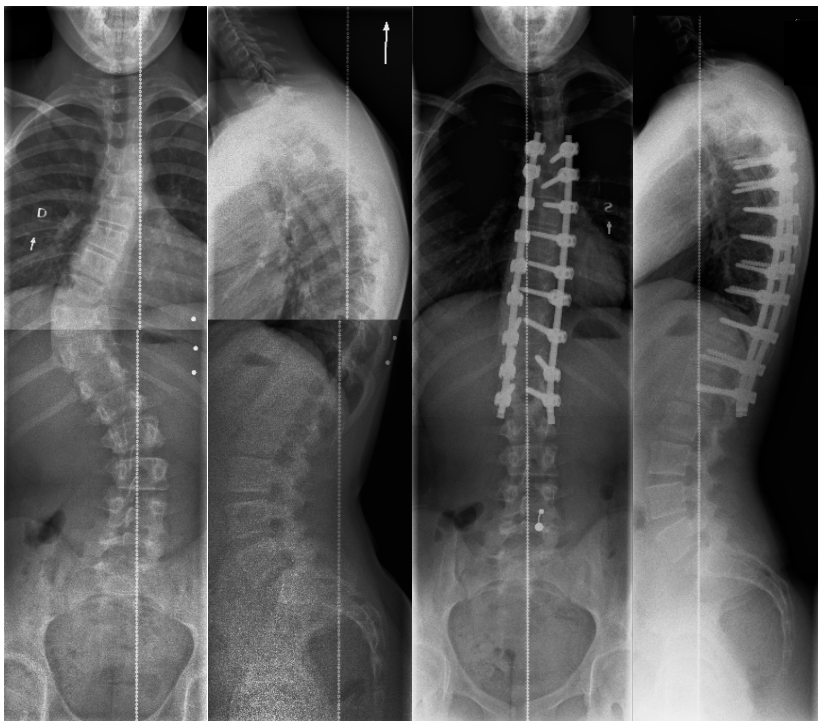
JIS: Figs. 2-A to 2-C. 11-year-old girl with juvenile idiopathic scoliosis (Risser 0). Preoperative standing radiographs (A, B) demonstrate 60-degree thoracic scoliosis. Standing radiographs (C, D) at two-year FU demonstrate fusion after PSI with no adding-on and normal TK.
